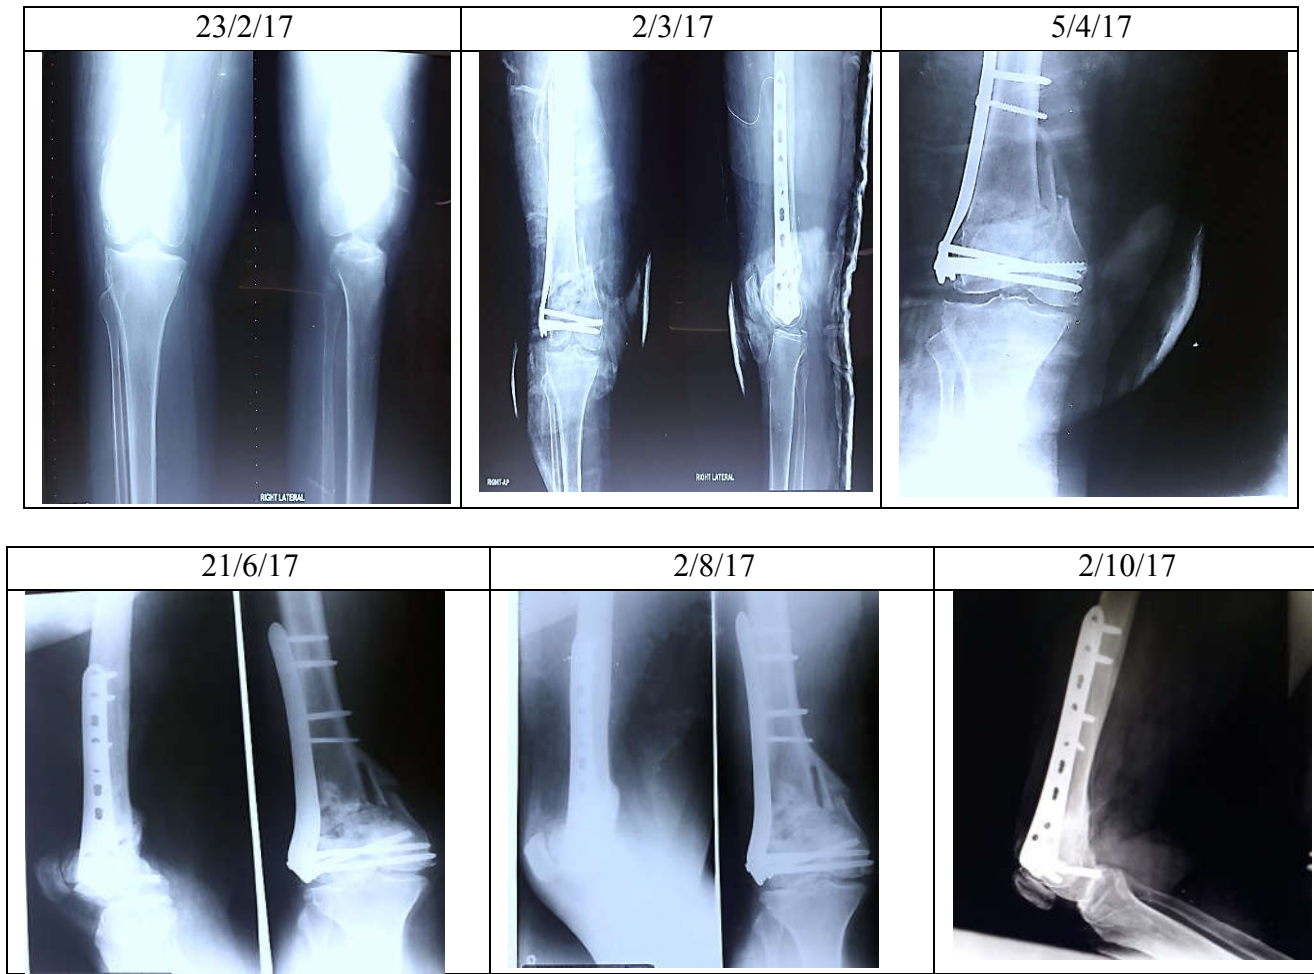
X-ray distal end of right femur antero-posterior & lateral view of case 1
